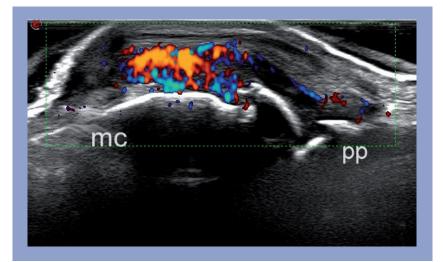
Longitudinal ultrasonographic image of the dorsal aspect of a metacarpophalangeal joint shows marked grayscale synovitis (grade 3) and marked power Doppler signal (grade 3). mc: Metacarpal bone; pp: Proximal phalanx.
